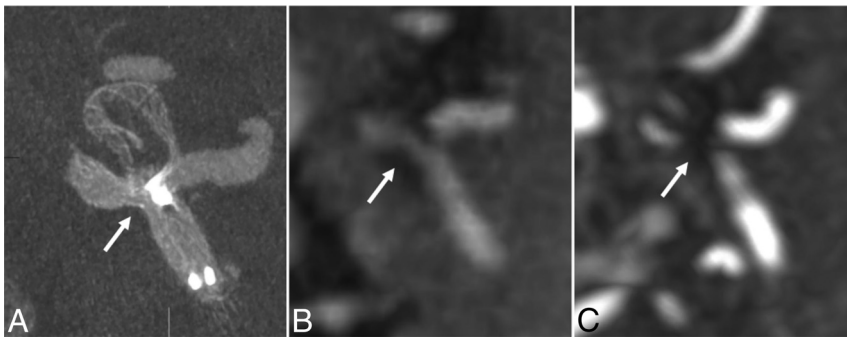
Example of an AcomA aneurysm treated with WEB and stent in the A1-A2 junction due to protrusion of the WEB after detachment. Note the visualization of the patent stent lumen in flat-panel detector CT with intra-arterial contrast injection (A, arrow) and UTE-MRI (B, arrow). In contrast-enhanced TOF-MRA (C), the in-stent lumen adjacent to the proximal marker cannot be visualized (arrow).
